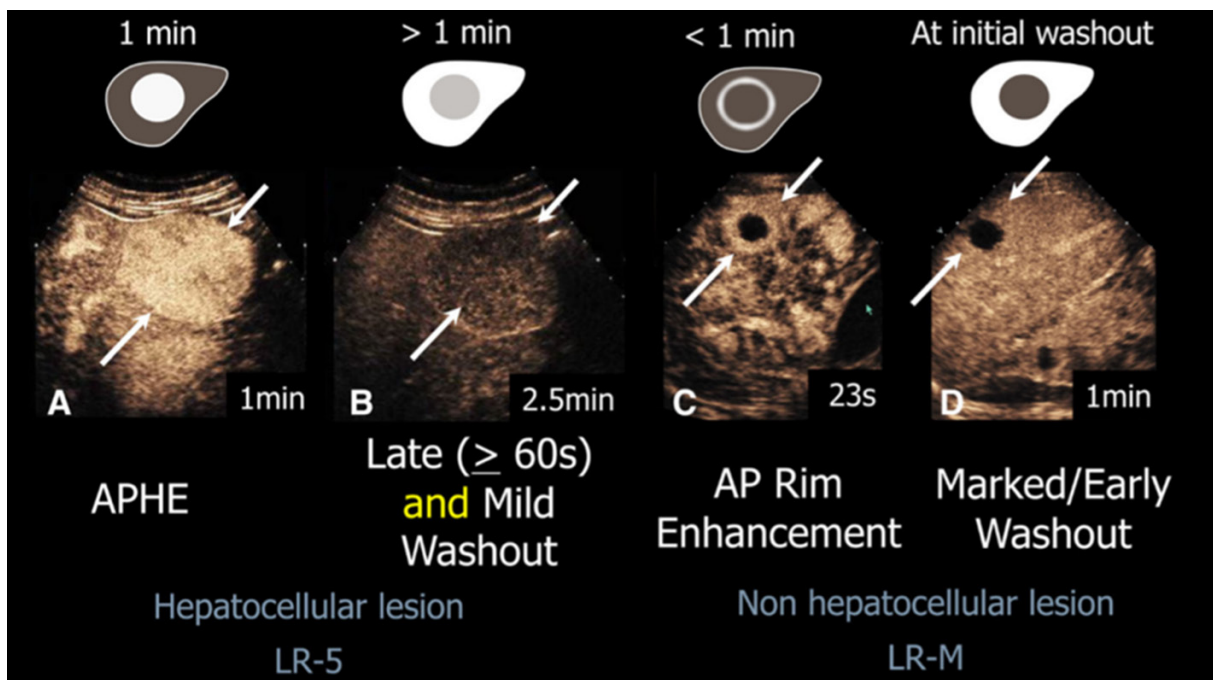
Contrast-enhanced ultrasound Liver Imaging Reporting and Data System. LR: Liver Imaging Reporting and Data System (LI-RADS); US: ultrasound; CEUS: contrast-enhanced ultrasound; LR-NC: LI-RADS noncategorizable; TIV: tumor in vein; HCC: hepatocellular carcinoma; APHE: arterial phase hyperenhancement; LR-M: LI-RADS malignancy
